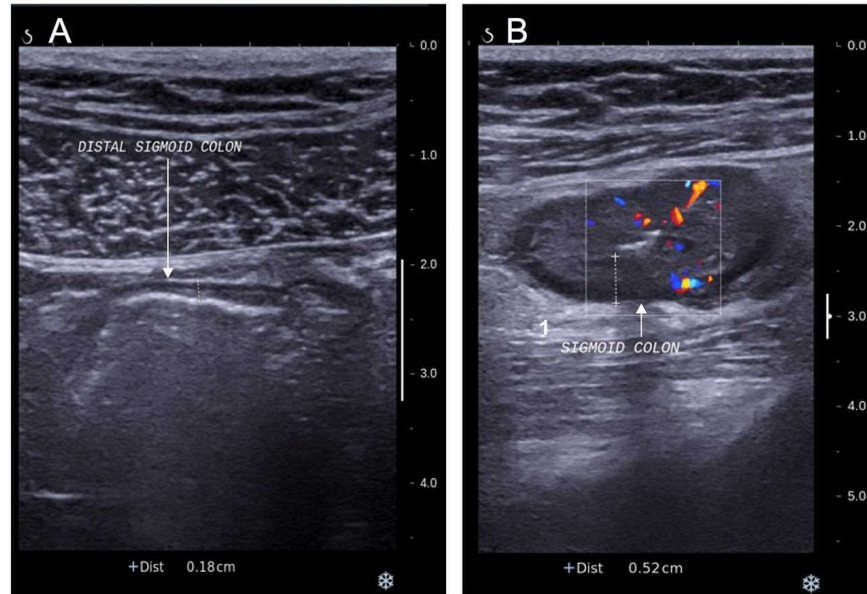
Ultrasonography in IBS
